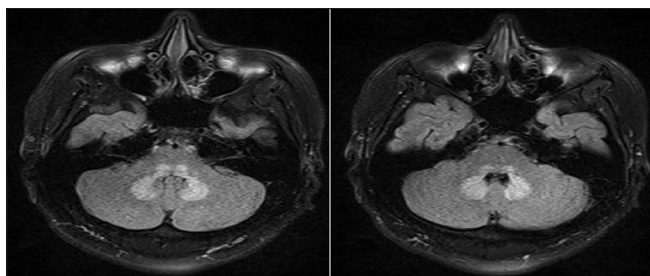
MRI FLAIR images of brain showing symmetrical areas of hyperintensities in the bilateral cerebellar dentate nuclei
